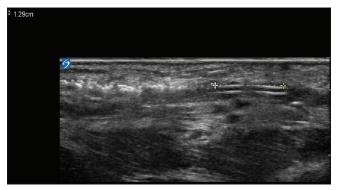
Ultrasound image of the right upper limb
